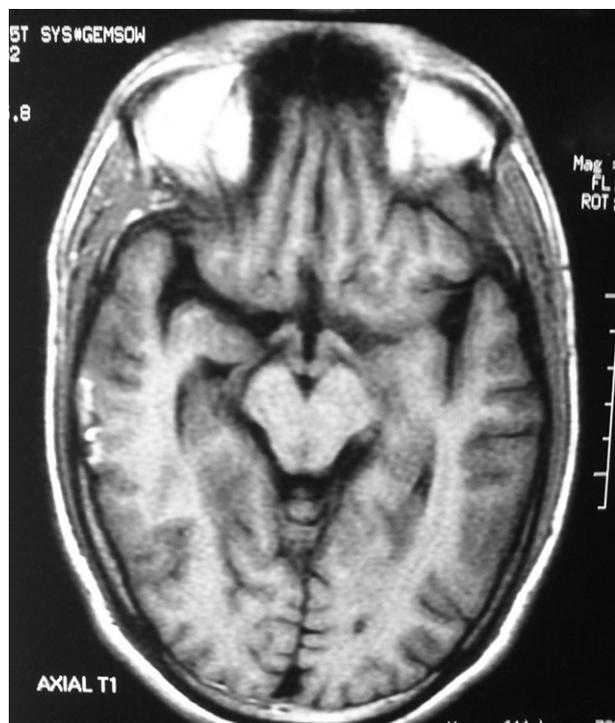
MRI brain showing multiple small contusions.
